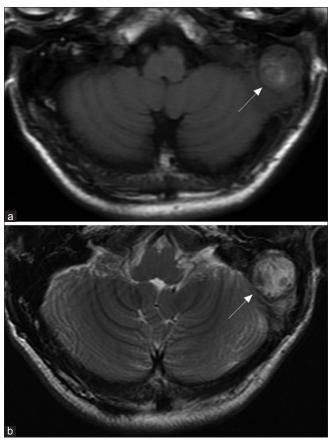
Axial magnetic resonance imaging of the left middle ear shows that the mass had mixed signal intensity with heterogeneous enhancement on T1- and T2-weighted images and well-defined margins, and was in contact with the sigmoid sinus (arrow showed). (a) T1-weighted images. (b) T2-weighted images
